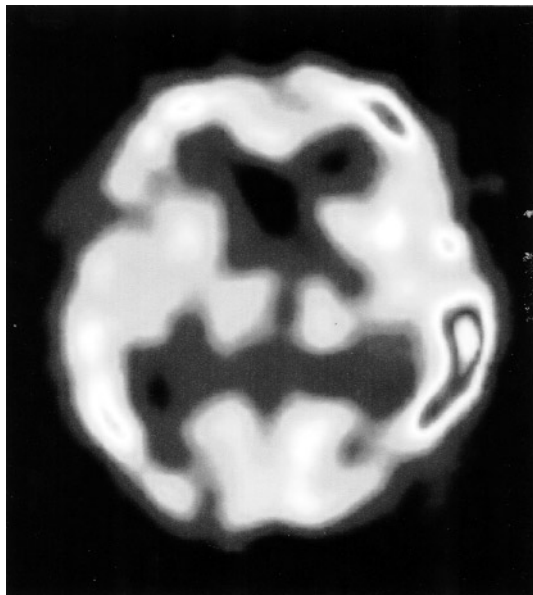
Single photon emission computed tomography. Case 1: Hypoperfused areas were found in the brain except for left frontal and parietal lobes.
